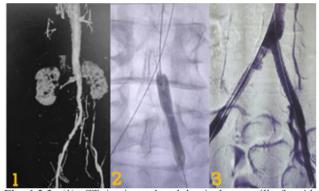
(1): CT Angiography abdominal aorta till cfa with 3d re-construction showing TASC D lesion of CIA; (2): Intra-operative angiography showing crossing both CIA lesions with Left CAI pre-dilatation; (3): Bilateral CIA stenting with Covered stent LIFE STREAM*.
